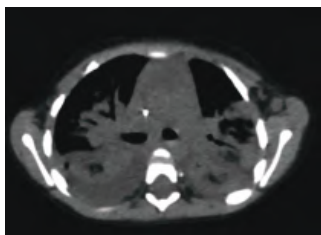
HRCT (Day 6 of admission)
